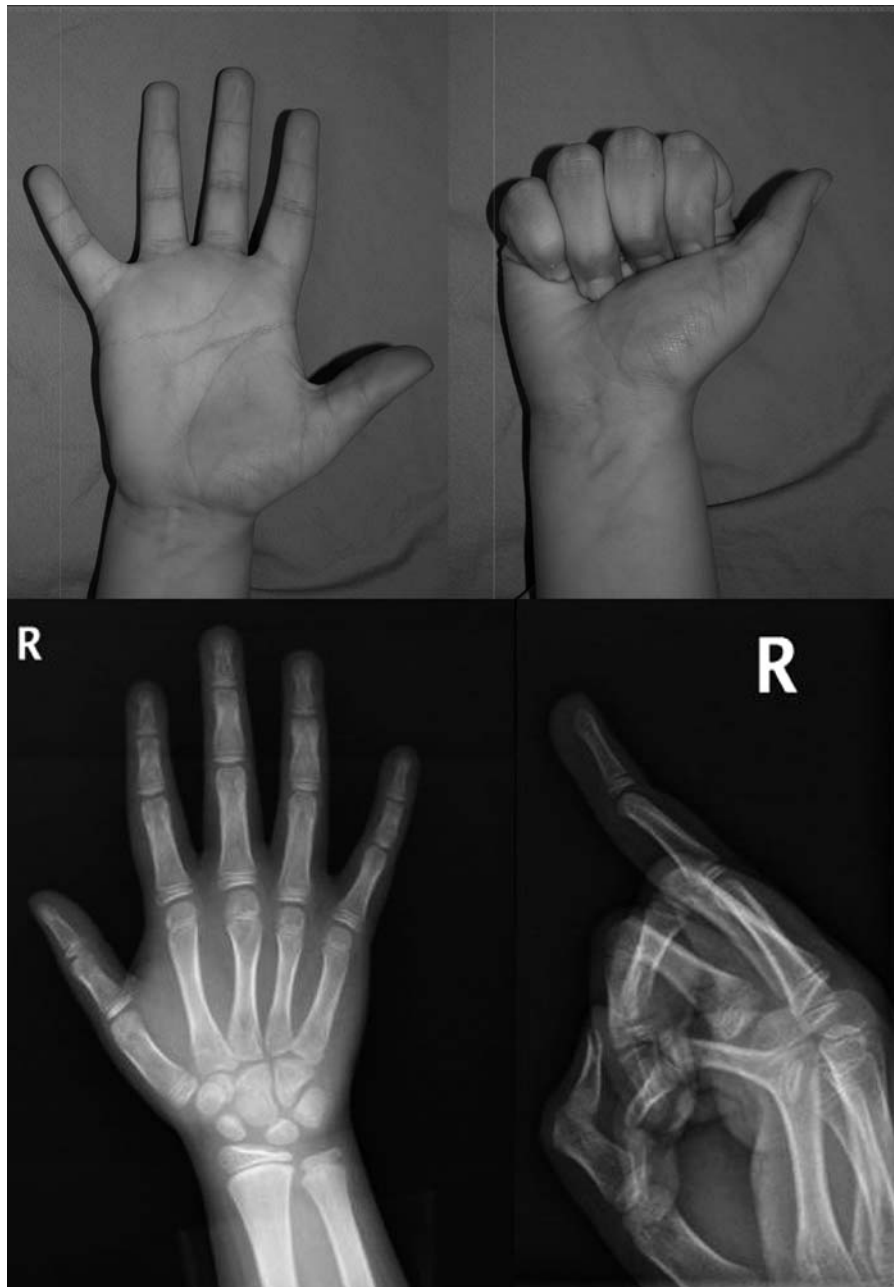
Clinical and radiographic images at 6 months postoperative.
